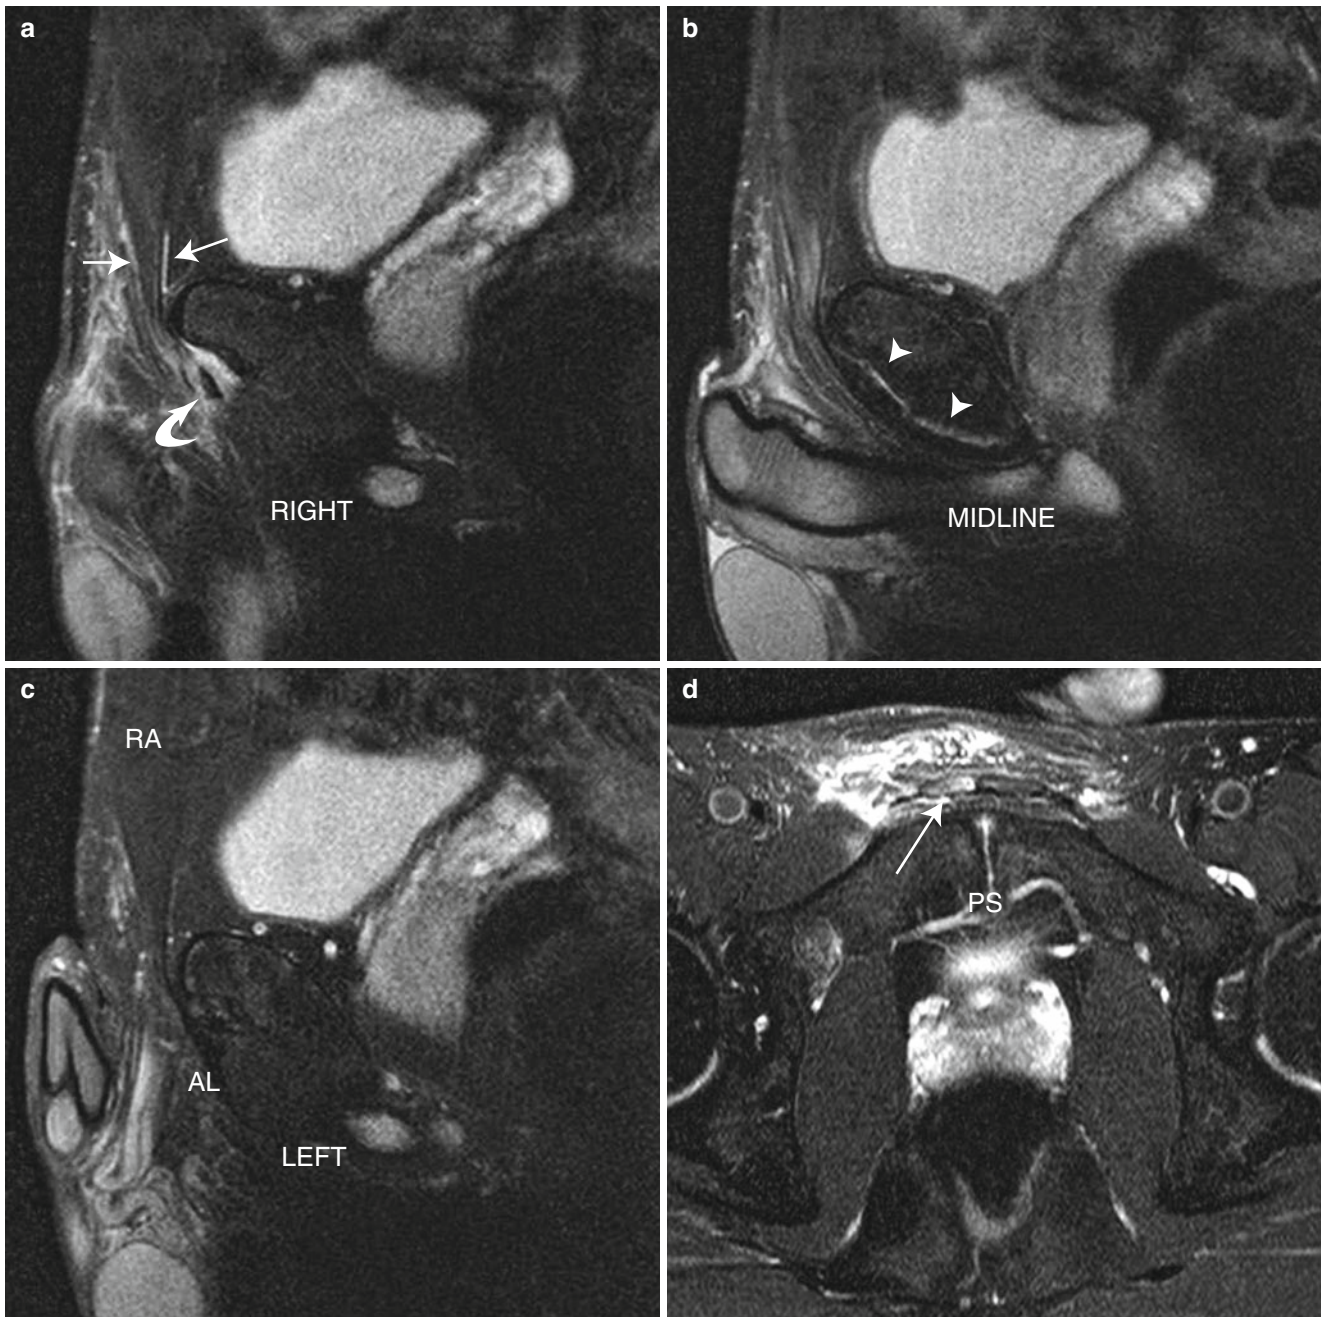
Sequential sagittal MR images from a dedicated athletic pubalgia/core injury MRI protocol on a baseball catcher (a, b, c) show a detached rectus abdominis and torn adductor longus on the right (*arrows*) with an extensive midline pubic plate disruption (*arrowheads*)
